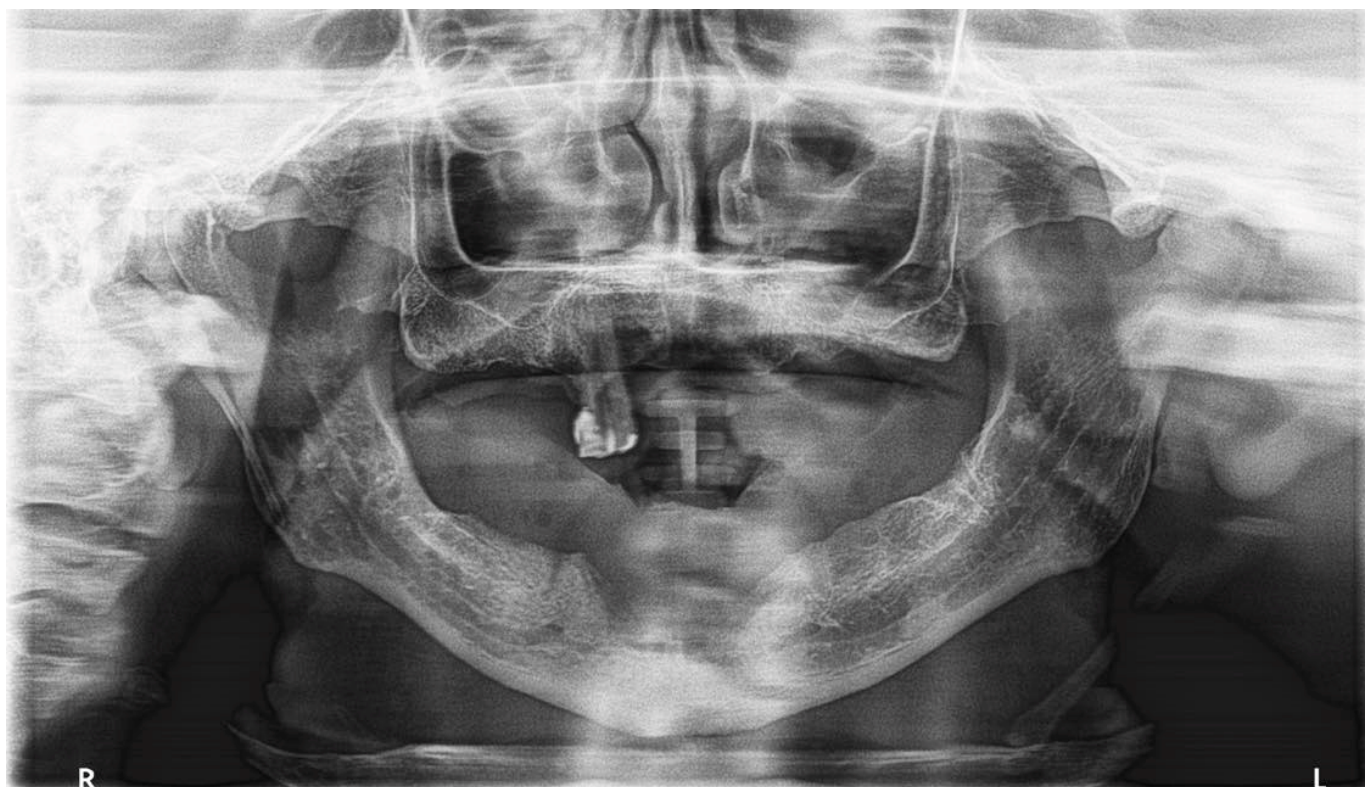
Postoperative control panoramic radiograph.
